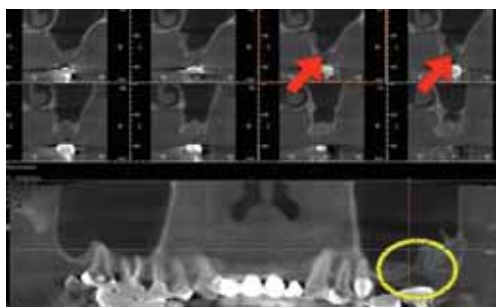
From the CT scan, bony opening was still there, but mucosal thickening was subsided.
